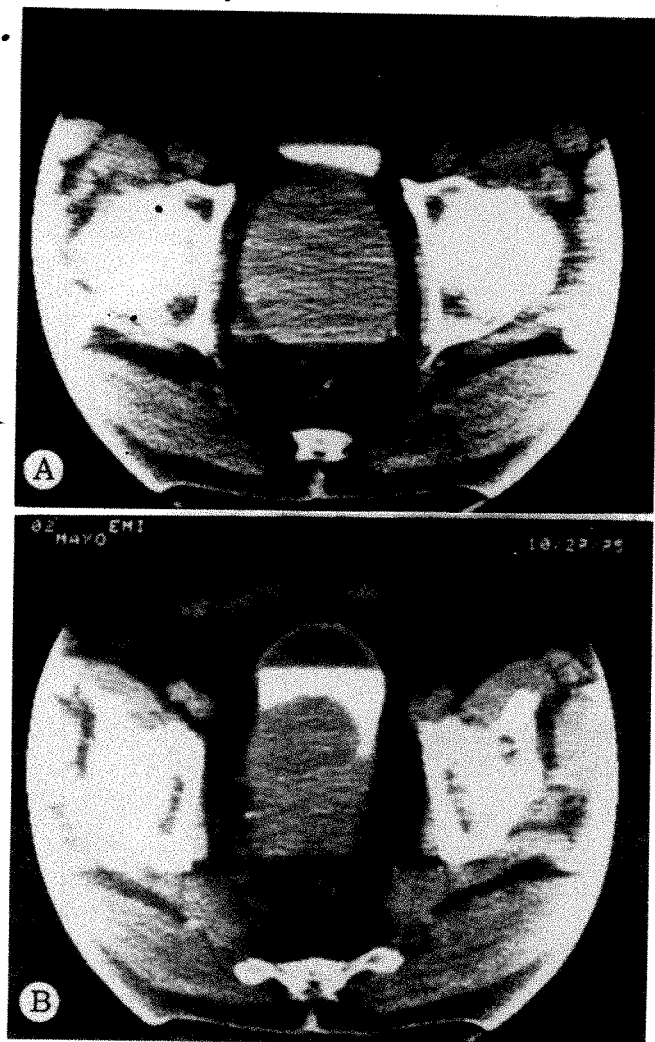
CT scans of 70-year-old man with symptoms of enlarged prostate. A, Scan through pelvis showing marked enlargement of prostate gland between rectum and bladder. B, Enlarged prostate gland indenting and deforming posterior aspect of bladder. Note fluid level representing interface between urine and contrast material in bladder. Bladder wall distinct from urine in bladder and from fat in lower pelvis.
